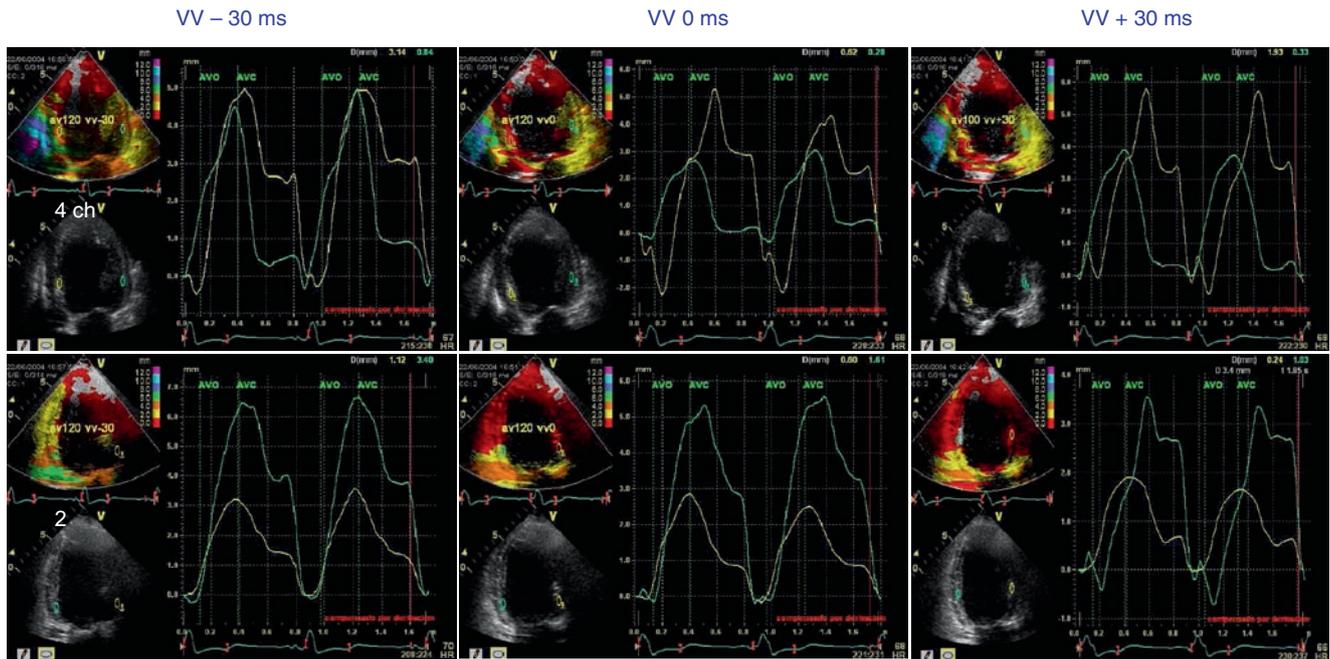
Optimization of the VV interval according to the iterative method using left ventricular dyssynchrony: The superposition of the displacement of two opposing walls is evaluated both in the 4- and 2-chamber apical walls with tissue Doppler imaging. The superposition and the amount of displacement were maximal with the setting of a VV interval of -30 ms, especially patent in the 4-chamber traces. In the 2-chamber images, there are no significant changes among the different VV intervals. These images come from the same patient shown in Fig. 21.3. The selected optimum VV interval was the same
